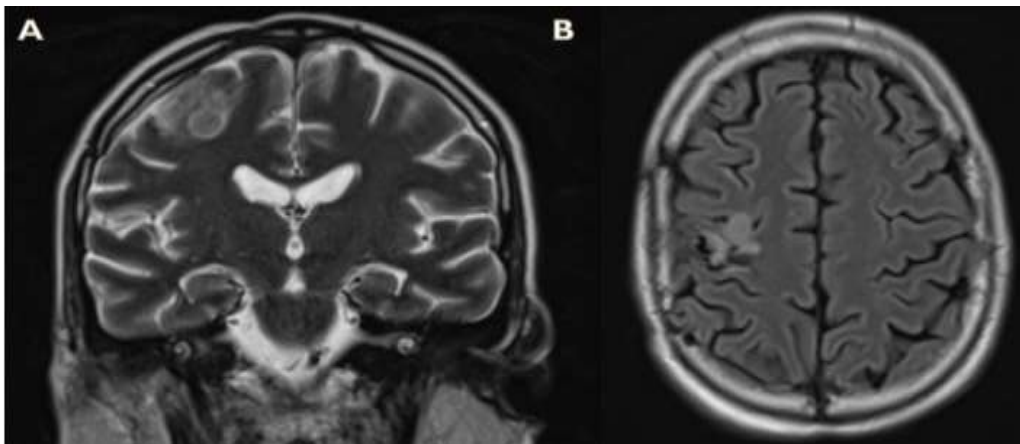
Morphological MRI signatures of CNS recurrence: (A) Coronal T2-weighted image demonstrating the marked hypointensity of the cortical-subcortical nodule (arrow). (B) Axial FLAIR image showing the hyperintense signal of the recurrence with associated gyriform infiltration
